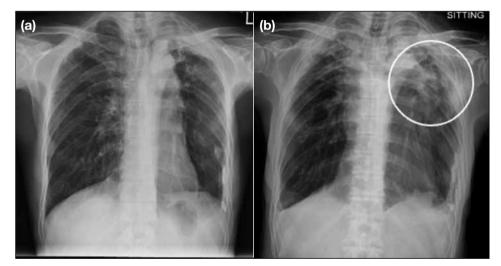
(a) Chest radiograph of the patient 6 years previously. (b) Current chest radiograph showing progression of left upper zone opacification (circle) compared with that 6 years ago.
